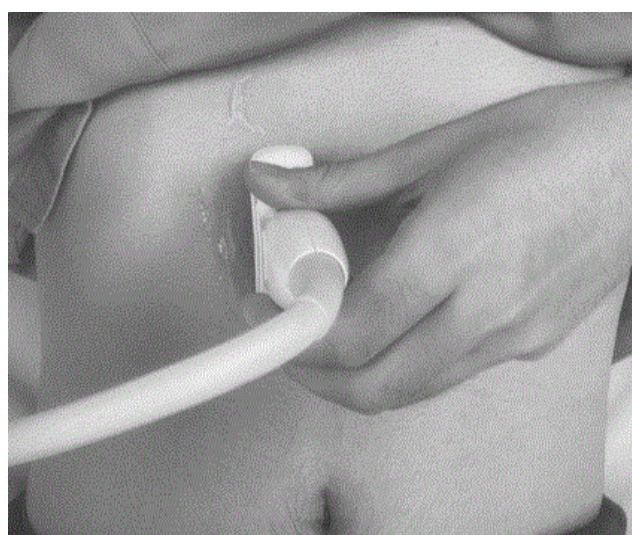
Measurement of the cross-sectional area of the gastric antrum by ultrasonography. (A) The ultrasound probe was applied longitudinally to the midline of the upper abdomen, offset slightly to the right, with the patient in the right lateral decubitus position. (B) The cross-sectional area of the gastric antrum was depicted while aiming at the inferior vena cava or aorta and superior mesenteric artery (SMA).
